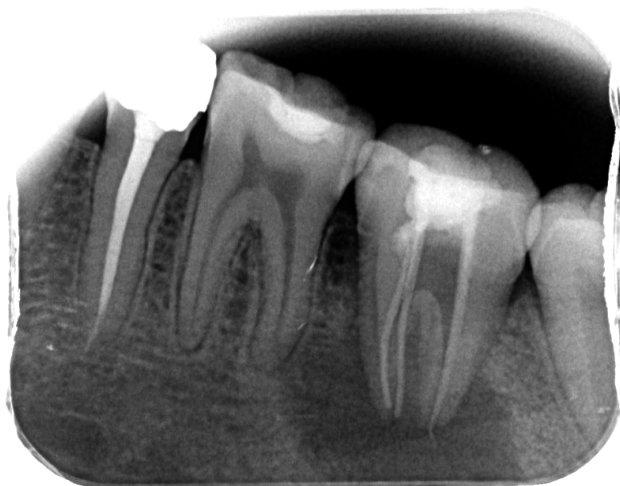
Diagnostic periapical radiograph
